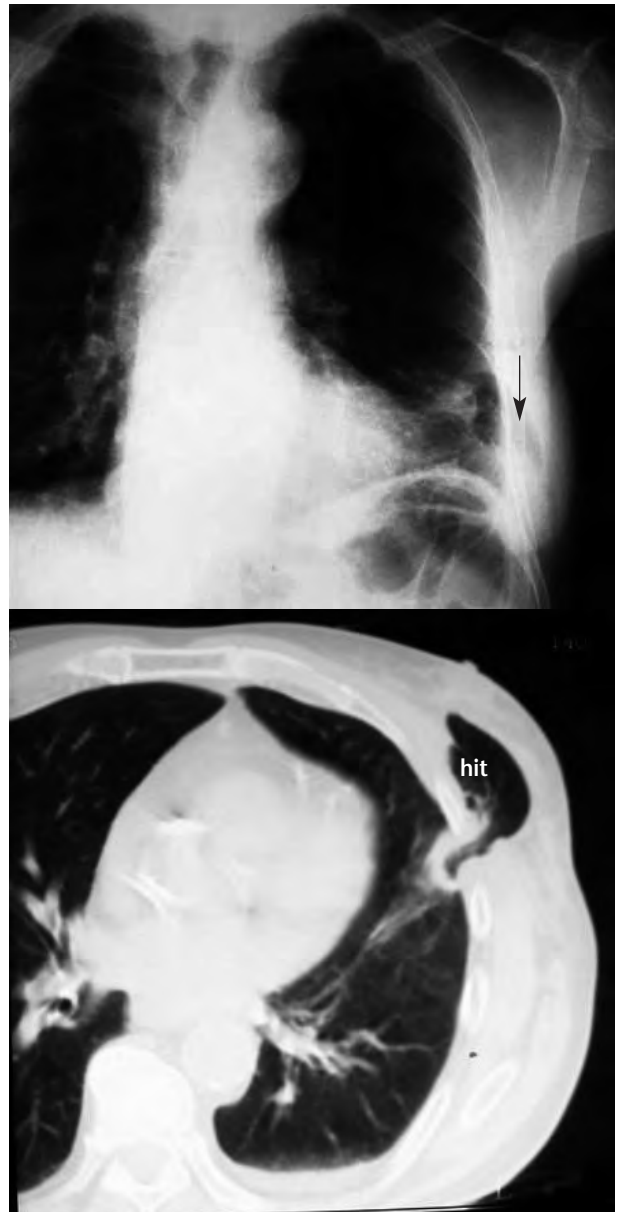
Plain chest X-ray (top) showing left lung contusion secondary to a fracture of the 7th left rib, and image compatible with intercostal hernia in the 7th left intercostal space (arrow). Computed tomography scan of the lower chest (below). Traumatic intercostal hernia (hit), uncomplicated and without pneumothorax, hemothorax or associated pleural effusion.
